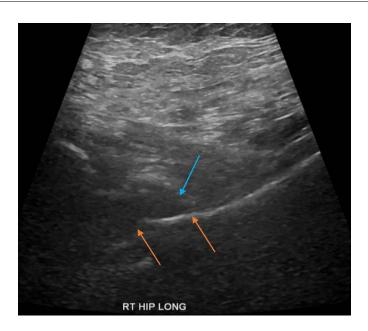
Right hip ultrasound performed in 2022 revealed synovial thickening of the joint capsule (blue arrow). Note that the continuation to the normal rounded femoral head could not be readily identified. The orange arrows outline the anterior femoral neck, and the left side of the image is more cephalad, or at the hip joint.
